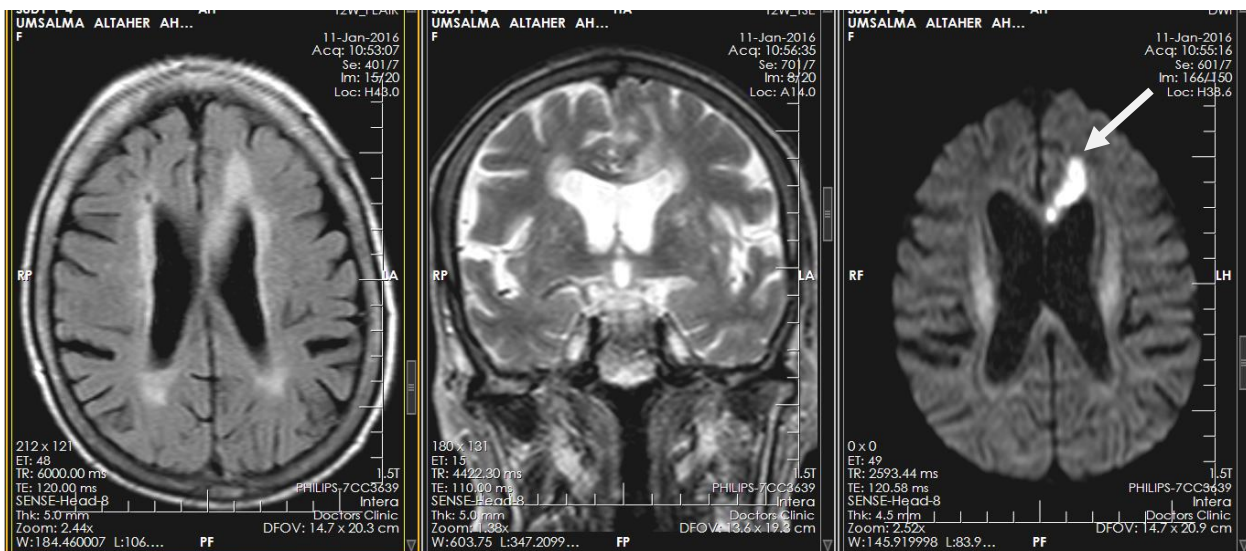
Axial FLAIR, coronal T2 and axial DWI showing Left corpus callosum acute cerebral ischemic infarct for female patient 60 years old.
